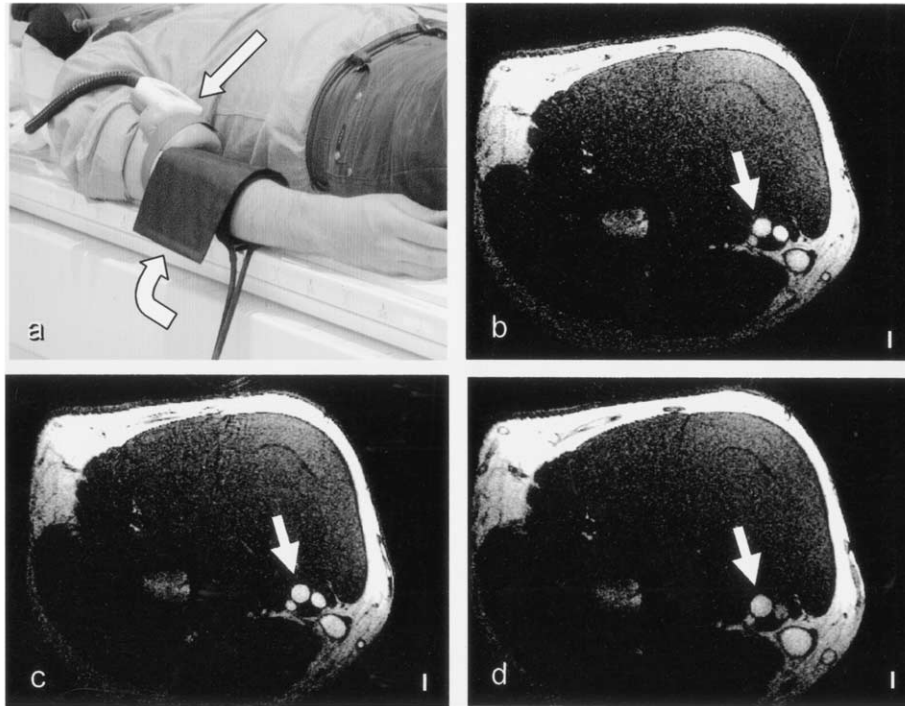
Magnetic resonance imaging (MRI) of brachial artery reactivity to hyperemia. (a) Set up for brachial artery imaging in the magnetic resonance scanner with a pressure cuff on the forearm distal to the imaging site (curved arrow) and a surface coil placed above the elbow region for optimal magnetic resonance signal detection (straight arrow). (b to d) High-resolution MRIs aligned perpendicular to the brachial artery (arrows). (b) Baseline conditions (scale bar = 3 mm). Note the increase in brachial artery cross-section area (c) 1 min after cuff release (representing flow-mediated dilation) and (d) 3 min after GTN application (endothelium-independent relaxation).
